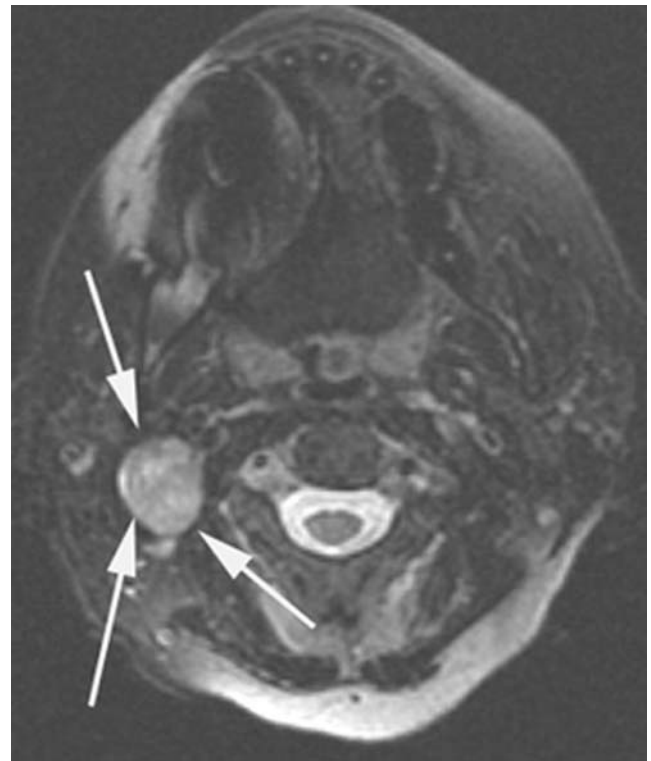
Ectopic parathyroid adenoma. Axial T2-weighted MR image of the neck in a 60-year-old female with hyperparathyroidism not responsive to bilateral parathyroidectomy reveals a round hyperintense lesion in the right neck parapharyngeal space, which was surgically proven to be an ectopic PT adenoma (arrows)
